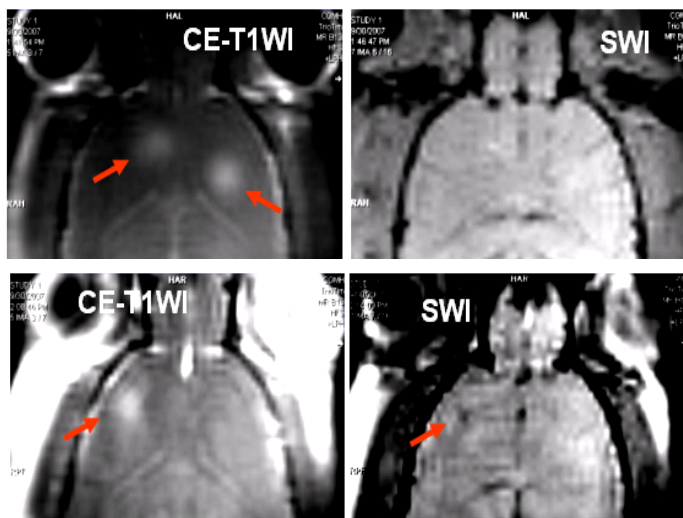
MRI at low (left two) and high (right two) power.
